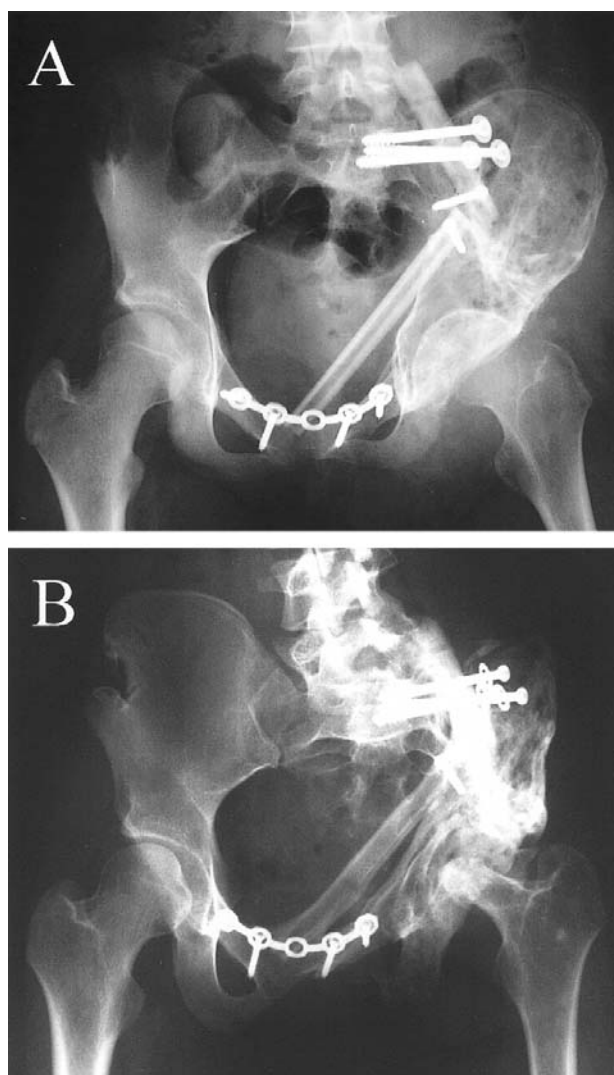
(A) An anteroposterior radiograph right after surgery. Limb-sparing surgery with wide excision and implantation of a hybrid autograft consisting of an irradiated osteoarticular and a vascularized fibula were performed. (B) Four years postoperatively, the structure of the pelvic ring was maintained. The collapse and shrinkage of the femoral head had progressed.
